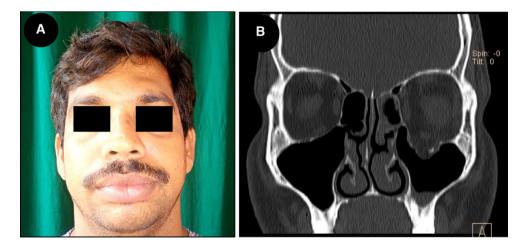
a Facial profile view showing *left* subconjunctival hemorrhage and enophthalmos. b CT scan coronal section showing prolapsed *left* orbital contents
